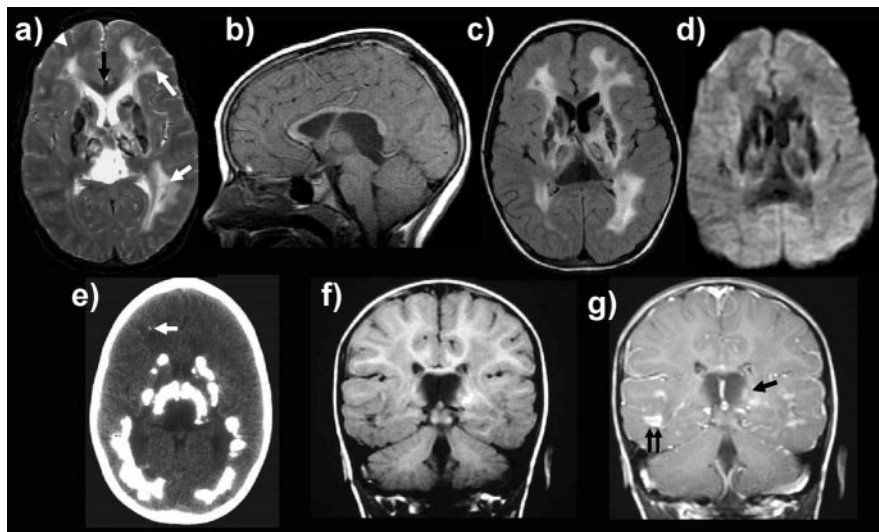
Patients 1 (E–G) and 2 (A–D): axial T2-weighted image (A) shows white matter hyperintensity (white arrows). Note sparing of U fibers (white arrowhead) and corpus callosum (black arrow), also seen on sagittal T1-weighted (B). Axial fluid-attenuated inversion recovery image (FLAIR) (C) confirms the cystic nature of the interhemispheric lesion. Axial diffusion-weighted image (D; repetition time/echo time, 10,000/120 ms; three orthogonal gradient directions; single-shot spin-echo echo-planar imaging (SE EPI); and b_{max} 1000 s/mm^2) shows no water restriction in the cyst or parenchyma. Nonenhanced CT (E) shows extensive and coarse calcifications in the basal ganglia, thalamus, and parietal white matter. Note
